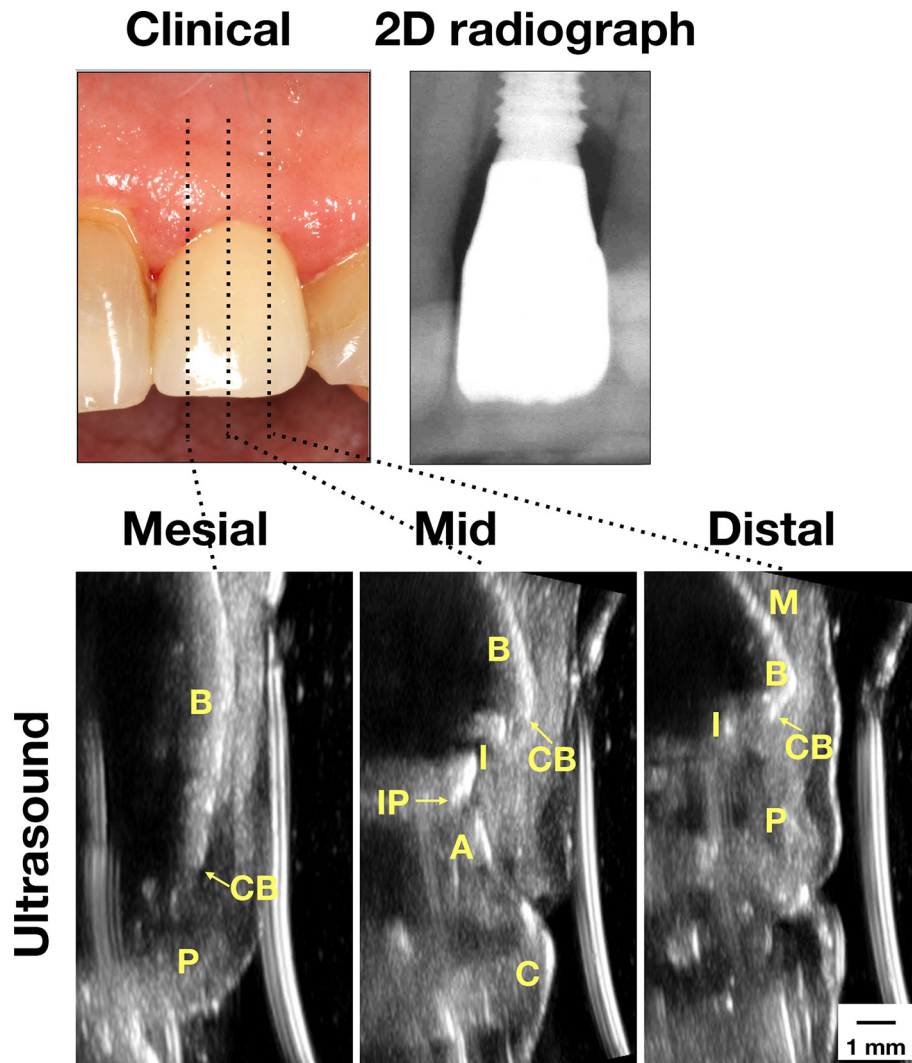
Case demonstration of an implant with peri-implant mucositis. Clinically, the mucosa swelled and bled upon probing. Normal bone level was found on the peri-apical film. Ultrasound images on the mesial, mid-facial, and distal sites showed normal bone level as well. 2D, two-dimensional; A, abutment; B, bone; C, crown; CB, crestal bone; I, implant; IP, implant platform; M, mucosa; P, papilla).
